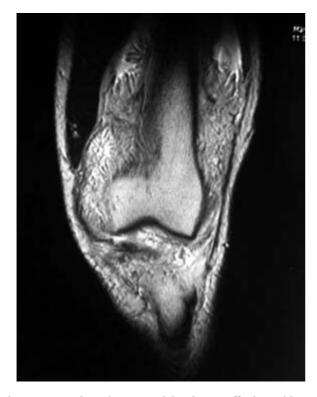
Coronal section T2-weighted MRI, effusion with villous mass in supra-patellar area.
